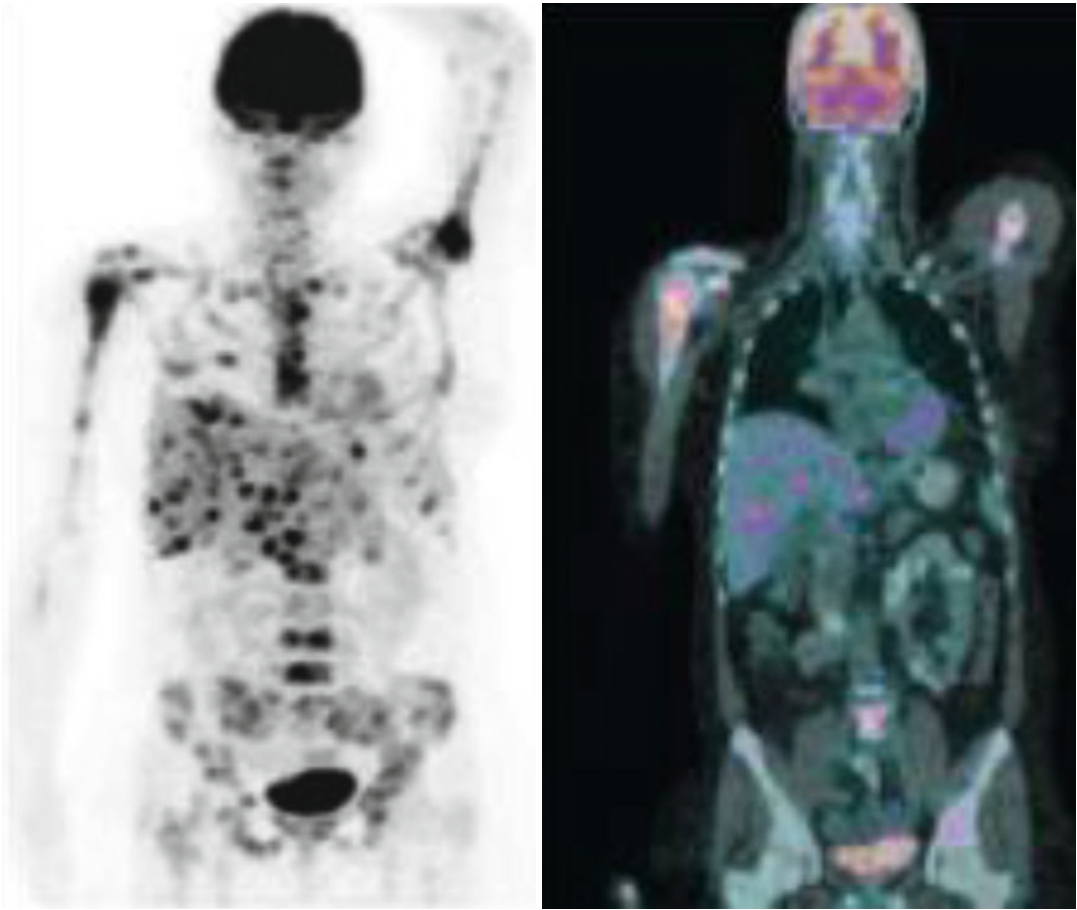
Staging of breast cancer. FDG image (*left side*) and coronal fused images (*right side*) of 18 F-FDG PET-CT showed extensive metastases in the liver and skeleton
